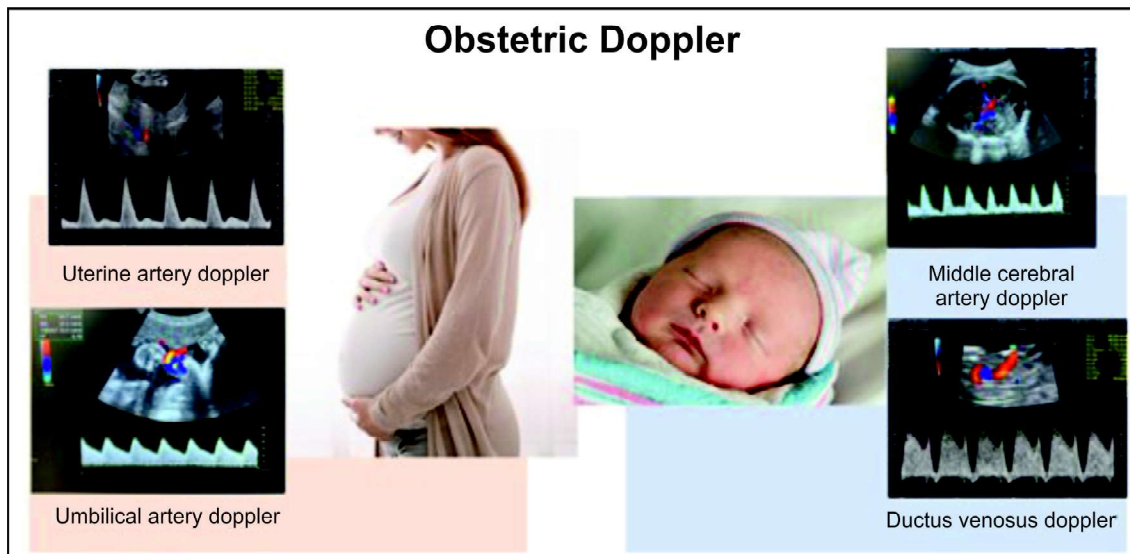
Dopplers depicting fetomaternal pathology
